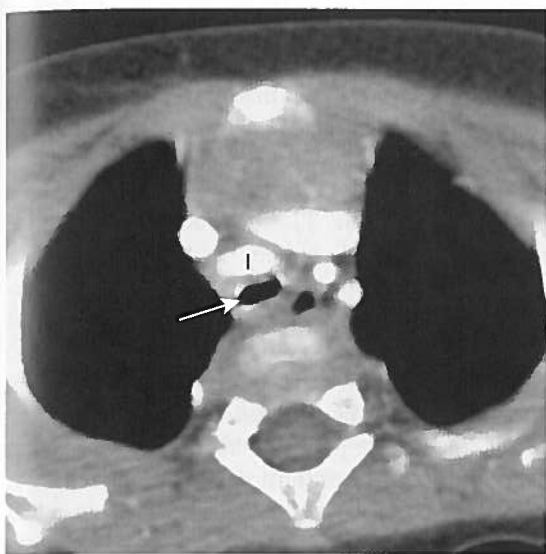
Right-sided aortic arch with aberrant left subclavian artery and associated airway compression. A, Frontal radiograph showing trachea deviated leftward, with soft tissue impression in the rightward aspect of the trachea, consistent with right aortic arch. B, Lateral radiograph showing trachea (*arrow*) to be bowed anteriorly and to be compressed. C, CT showing right-sided aortic arch with aberrant left subclavian artery (*arrow*). The trachea is not compressed at this level. D, CT at more inferior level showing compression of right main bronchus (*arrow*) secondary to midline position of descending aorta (*D*), associated with descending aorta starting on right superiorly and crossing over to left more inferiorly. Abnormal stacking leads to airway compression.
